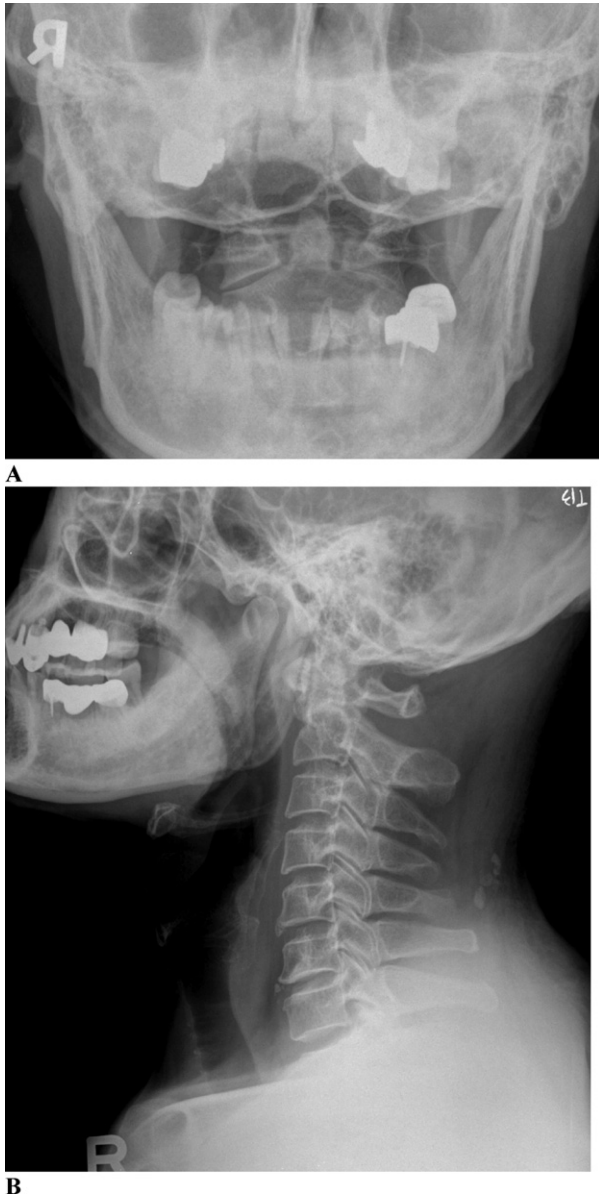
(A) Radiograph of open-mouth view of cervical spine that did not reveal fracture of the axis. (B) Radiography of lateral view of cervical spine did not reveal the widening of atlantal-dense distance.
